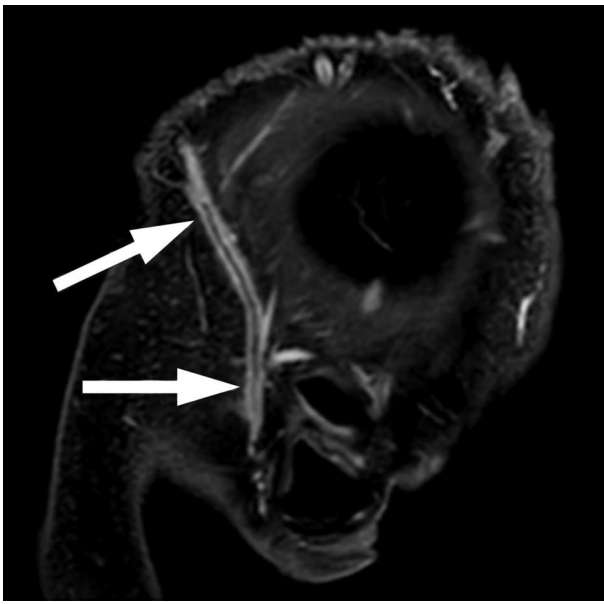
Sample sagittal MRI section showing thickening and parietal contrast enhancement of the external carotid and the superficial temporal arteries (arrows).
